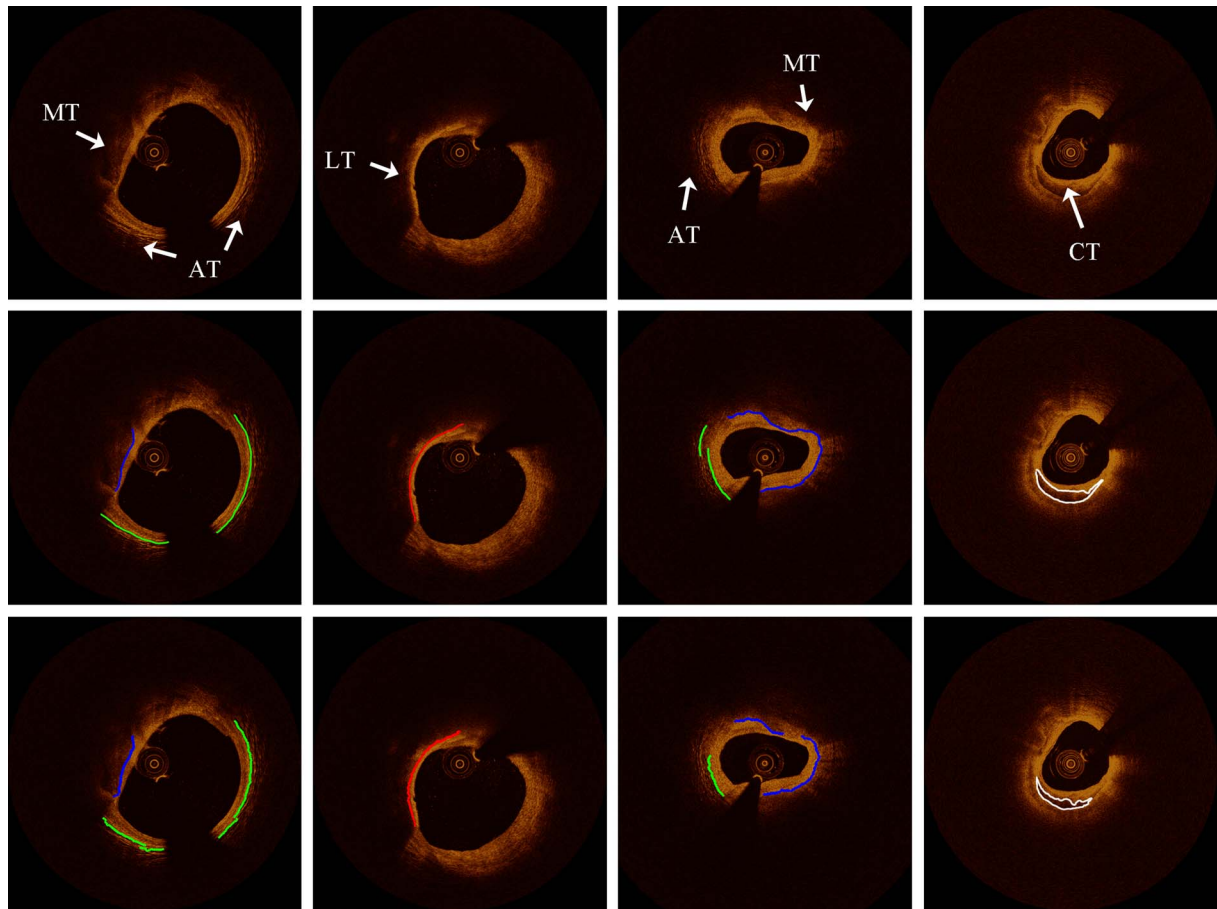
Results of tissue classification. The colors of the plaque contour indicate the tissue behind the border (green, AT; red, LT; blue, MT; and white, CT).
